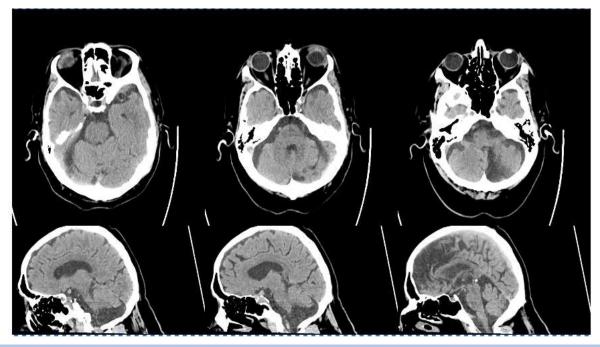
Non-contrast CT head axial and sagittal views upon first presentation to the Emergency Department demonstrating no evidence of parenchymal or extra-axial haemorrhage
